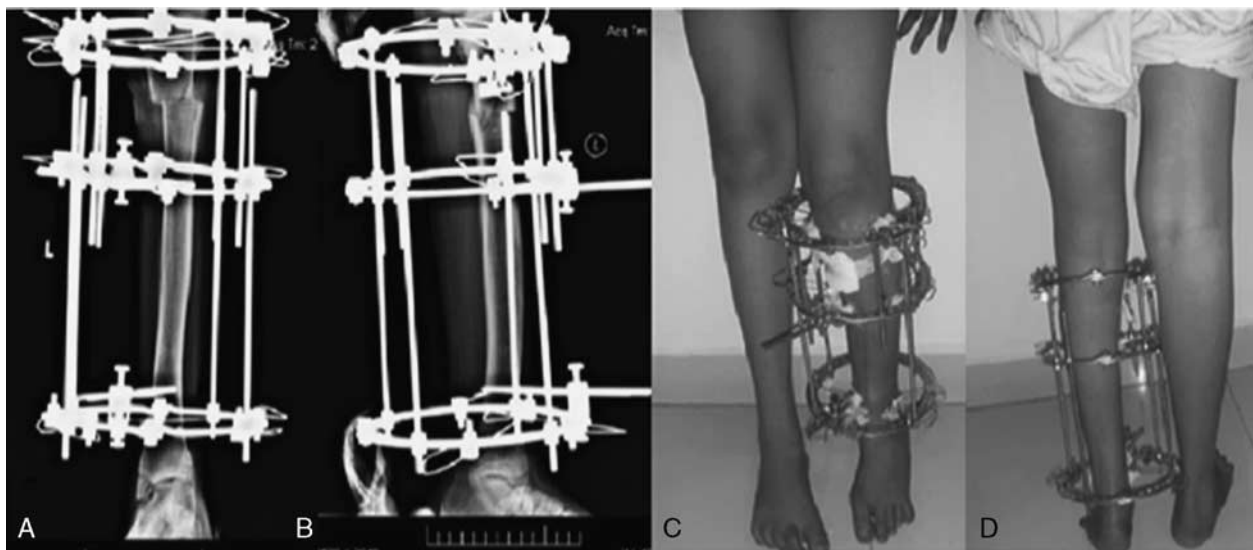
The rotation, genu valgum, and shortening in Figure 8 were treated with derotational osteotomy and lengthening of the tibia. An x-ray of the patient in the anteroposterior (A) and lateral views (B) with osteotomized tibia and stabilized using the Ilizarov method. Clinical pictures (C, D) of the patient showing both patellas facing forward with Ilizarov fixation in situ.
